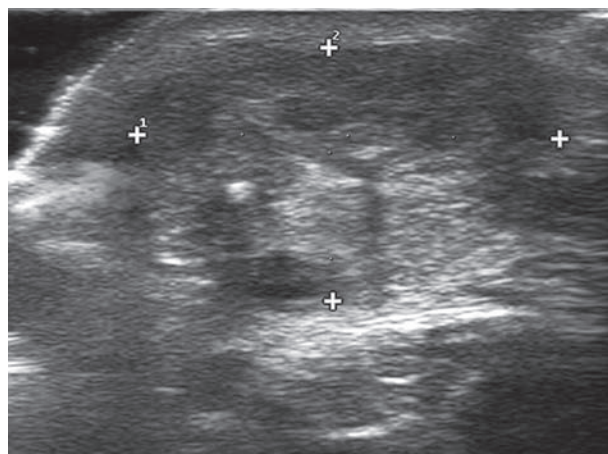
Transversal ultrasound scan of an operated Achille's tendon looking thicker and disomogeneous
